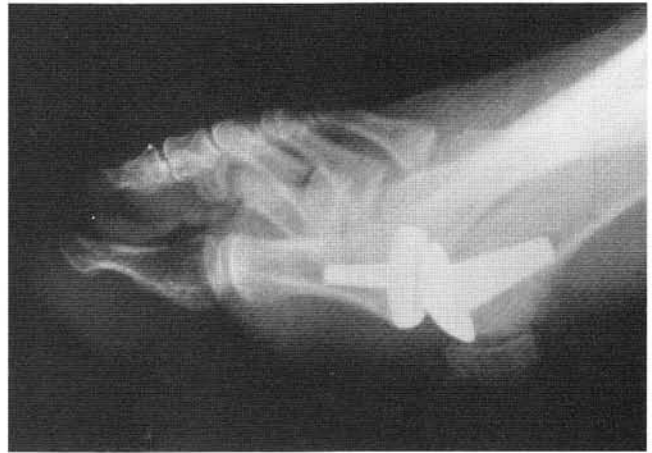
Lateral radiograph following salvage procedure.
